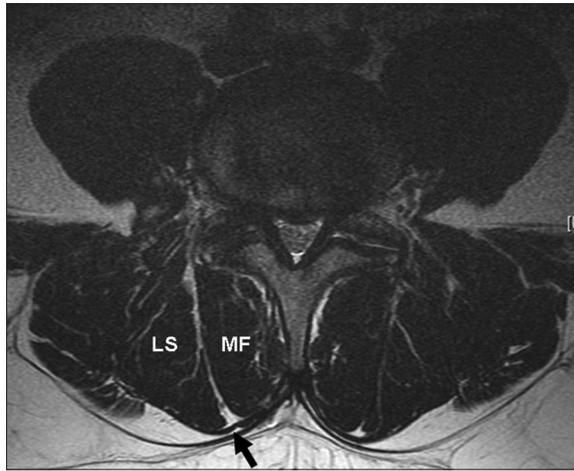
MRI of the axial view of lumbar spine and muscles. Arrow points to the path of Wiltse Approach, the muscle plane between the longissimus muscle (LS) and the multifidus muscle (MF)
